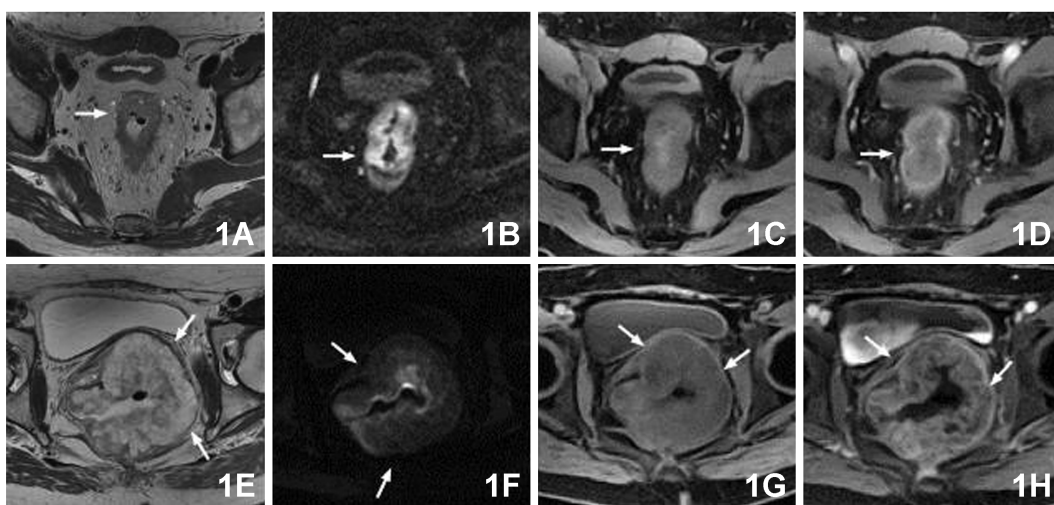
MRI image comparison between rectal adenocarcinoma and mucinous adenocarcinoma<sup>[1]</sup>
